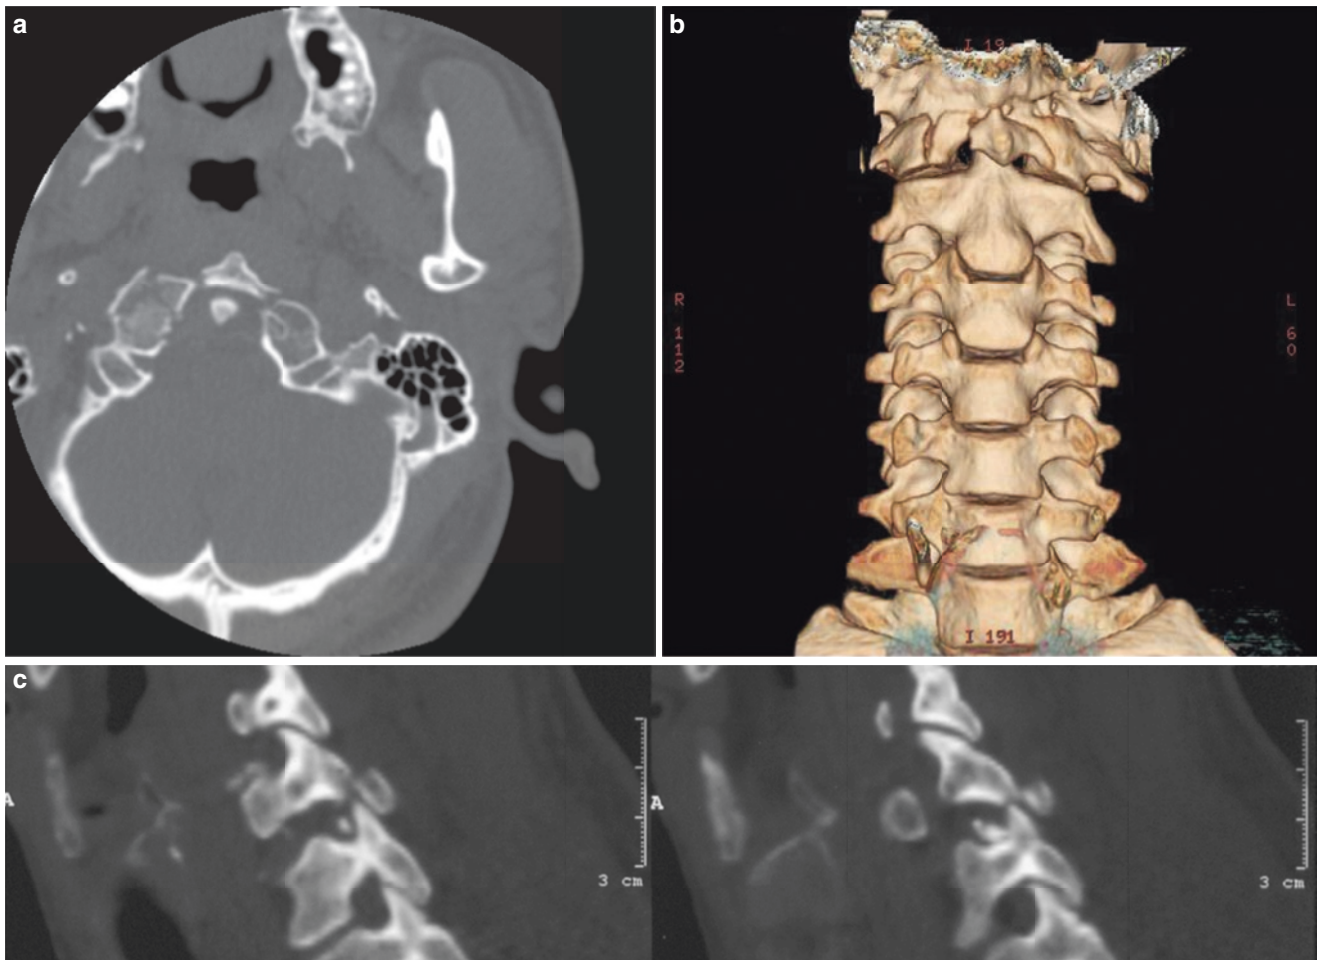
(a) Preoperative CT plain scan of a patient with an atlas fracture: The anterior arch of the atlas was fractured at two locations, and the right lateral mass was fractured. (b) The 3D reconstructed CT image of the same patient demonstrating the fracture dislocation stereoscopically and comprehensively. (c) The CT plain scan and 3D reconstructed image on the joint sagittal plane of another patient with cervical spine fracture and dislocation: joint interlocking can be displayed in detail
